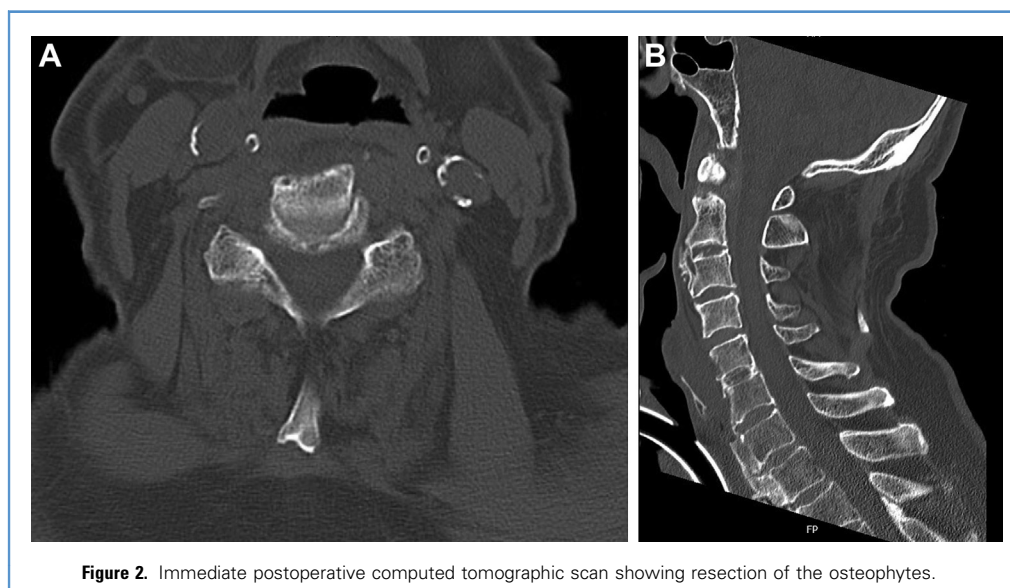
Immediate postoperative computed tomographic scan showing resection of the osteophytes.
